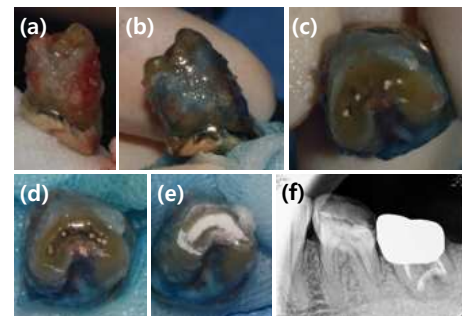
Intentional replantation procedure (a) #37 was carefully extracted using an extraction forcep (b) Root surface was dyed with methylene blue and rinsed to make sure there was no crack line (c) Root-end resection was done using tapered diamond bur (d) Retro-preparation using 330 tapered bur was made following original C-shaped canal (e) Retrograde filling was done using putty-type MTA(One-Fil®Putty, MEDICLUS, Korea) (f) Periapical radiograph was taken after tooth replantation
